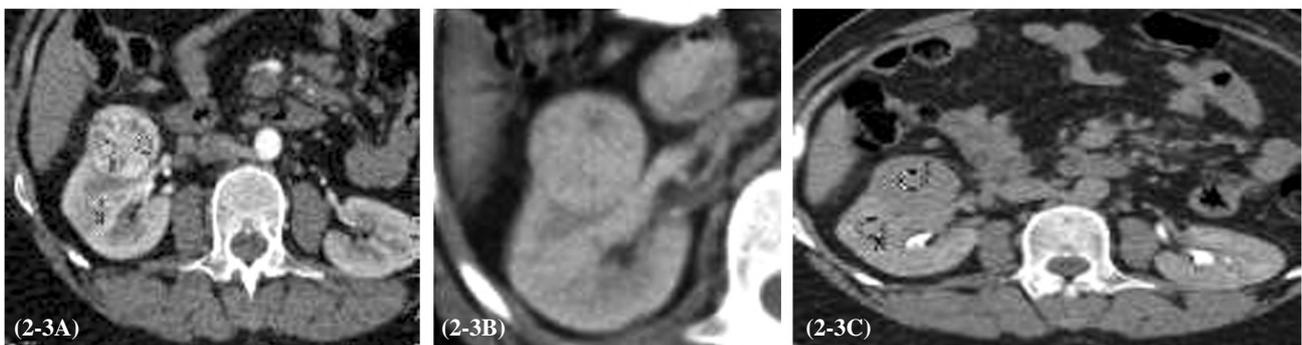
A, B, C: (Arterial, nephrographic and excretory phases) post contrast enhanced axial CT images obtained 1 month after 1 st RF ablation session show residual enhancing tumor tissues of previously ablated renal mass.
